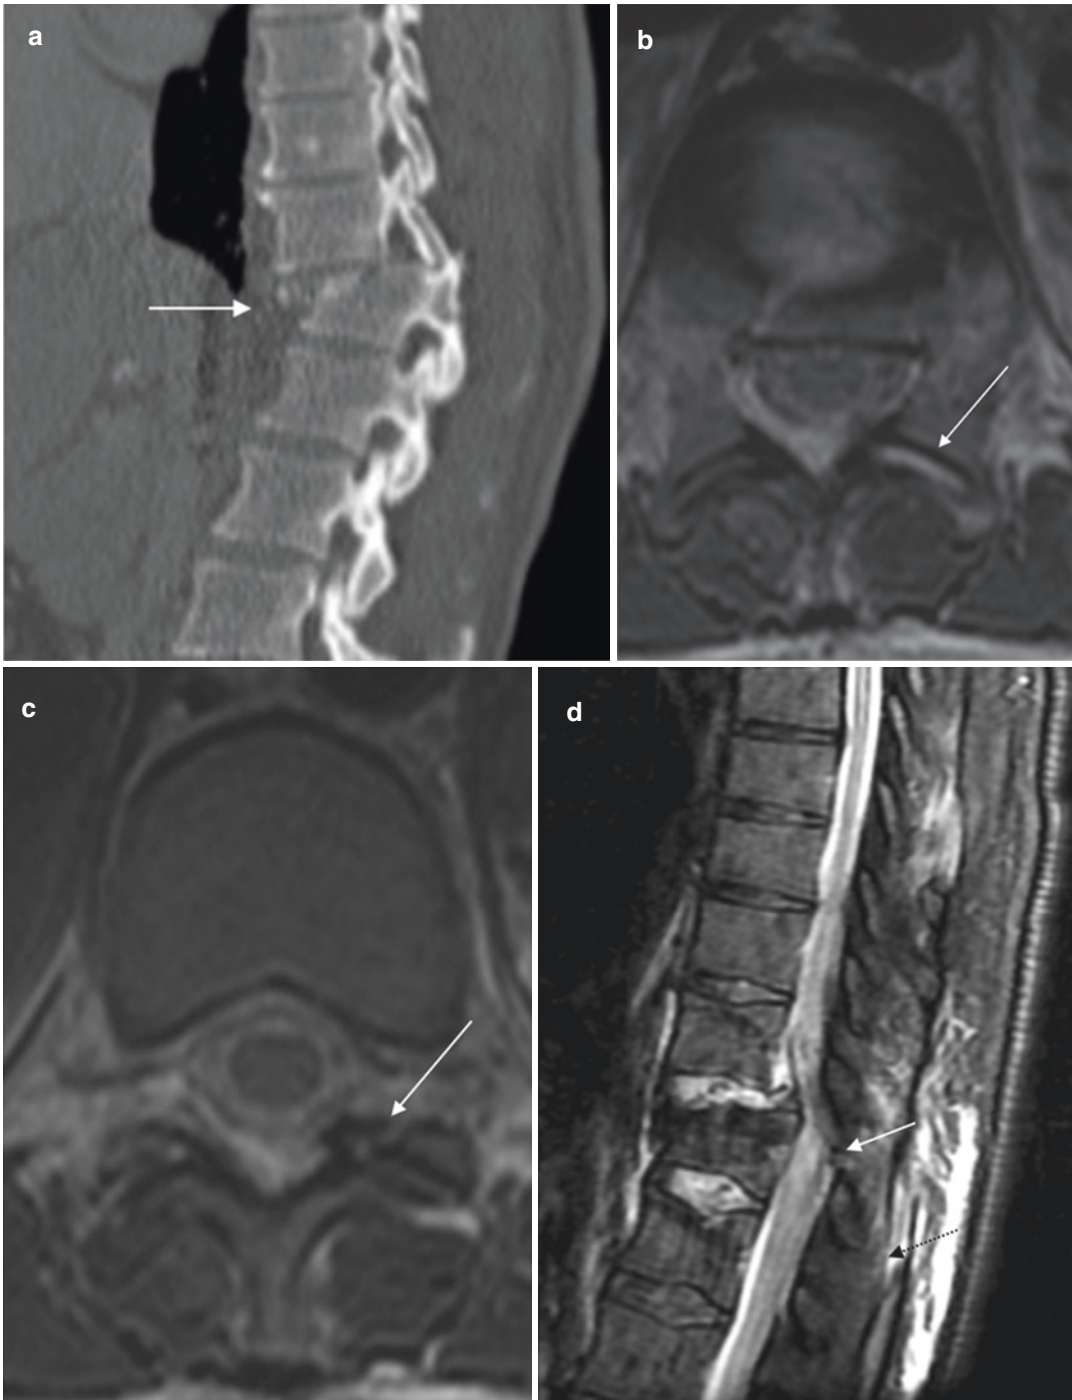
(a) Sagittal CT image of a patient who fell from a height, demonstrating a T12 fracture with a three-column dislocation at T11-T12 (white arrow). Axial T2 fat-saturated MRI images at T11-T12 showing (b) fluid in the left facet joint and (c) avulsion of the facet joint capsule
